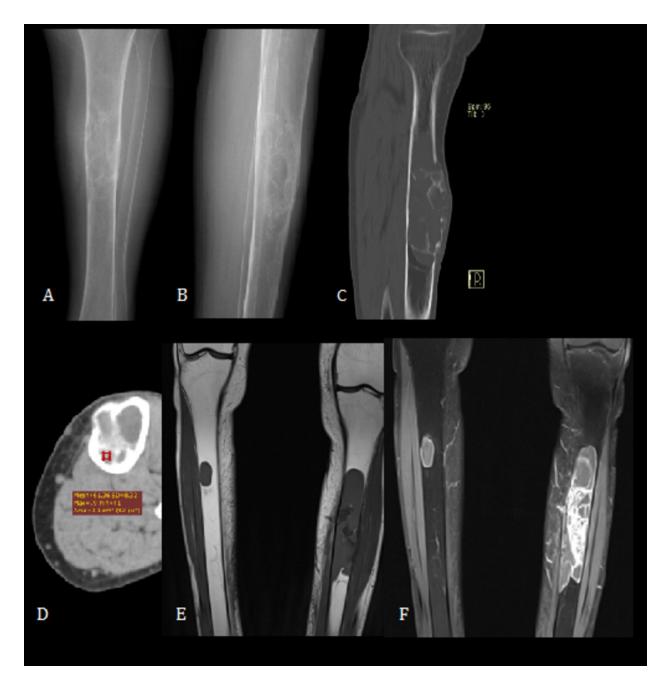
Hyperparathyroidism - Brown Tumors.Anteroposterior radiography (A) and Lateral radiography (B) show an eccentric expansive lytic well-marginated lesion with multiple septae in the left tibial diaphysis. Sagittal (C)and axial (D)computed tomography reformations show an expansive lesion with multiple septae with attenuation values of blood. Coronal T1 weighted image (D) and Coronal T1 FS after gadolinium administration (E) reveal a large eccentric hypointense well-defined lesion affecting the left tibial diaphysis and a smaller cortical lesion located in the right tibial diaphysis. Absence of soft tissue expansion.
